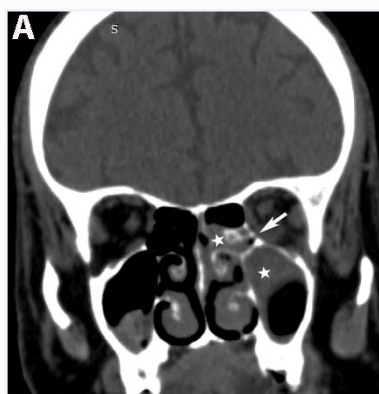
High resolution computed tomography of the paranasal sinus (coronal, soft window image) in patient no. 2 showing the presence of soft tissue involving left maxillary and ethmoid sinuses (stars) and rarefaction of the orbital rim (arrow).
